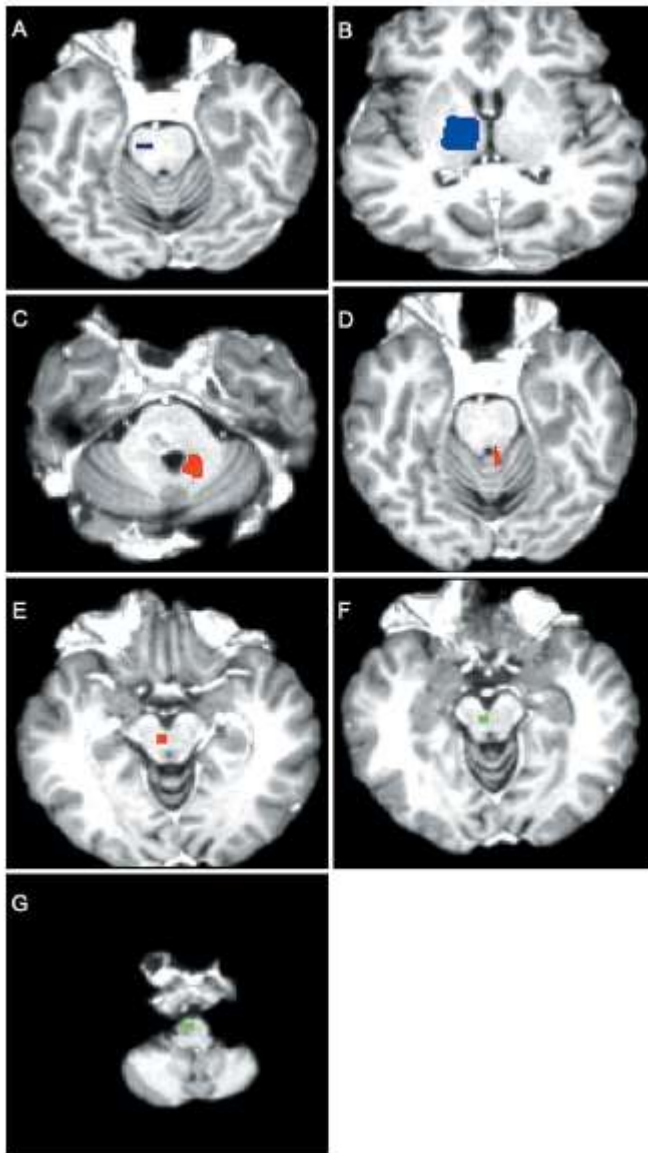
Axial T1-weighted MR images showing ROIs for reconstruction of the NST (blue areas), located at the level of the substantia nigra (A) and the ipsilateral striatum (B); of the DTT (red areas), located at the level of the dentate nucleus (C), the superior cerebellar peduncle (D), and the contralateral red nucleus (E); and the ROT (green areas), located at the level of the red nucleus (F) and the ipsilateral inferior olivary nucleus (G).
